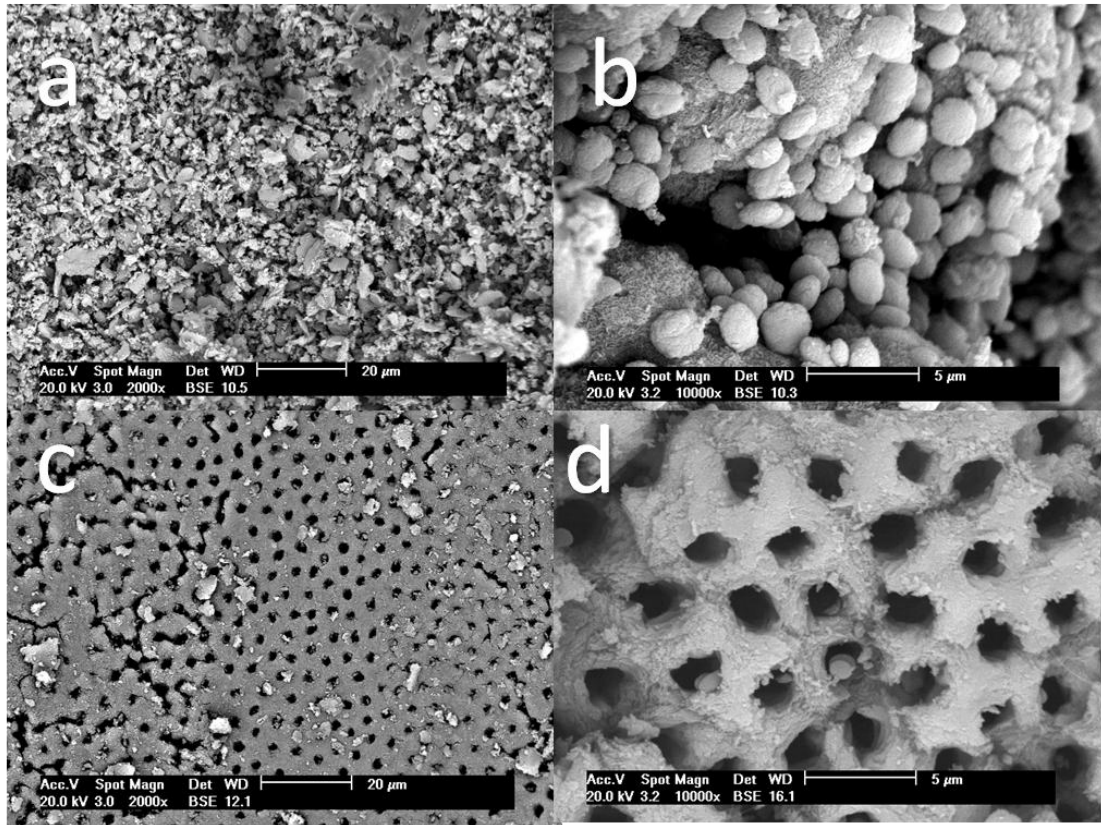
MEV of groups displaying cleanliness and decontamination features presenting the group that got better and worse results in the respective magnification. a. 2% Chlorhexidine gel (2000x); b. Distilled water (10000X); c. 2.5% sodium hypochlorite + ultrasonics (2000x); d. 2.5% sodium hypochlorite + ultrasonics (10000x).
